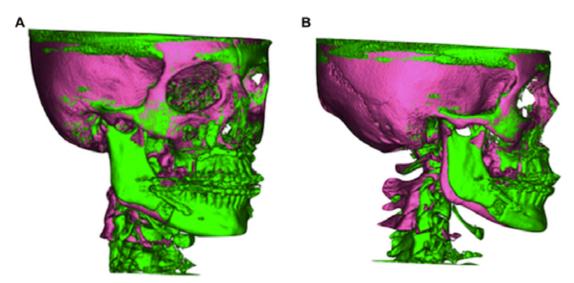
A, Preoperative and postoperative color map superimposition—front view. Color legend as follows: Pink, preoperative CBCT (T1); Green, postoperative CBCT (T1 or T2).B, Preoperative and postoperative color map superimposition—lateral view. Color legend as follows: Pink, preoperative CBCT (T0); Green, postoperative CBCT (T1 or T2).
